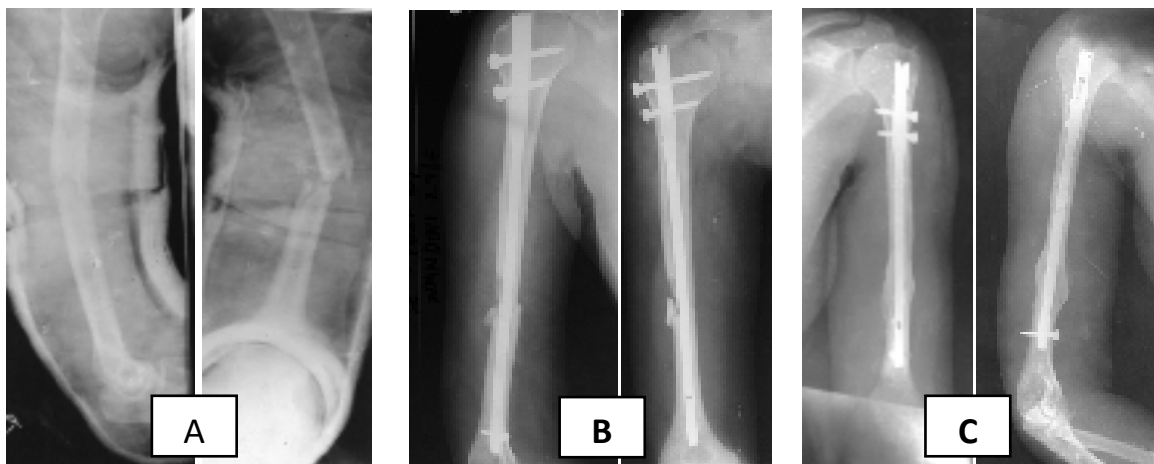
28 year old female fracture left humerus A-O type 12.B2 treated with Interlock nailing. (A) Pre-operative x-ray. (B) immediate post-operative x-ray. (C) 4 month post-operative x-ray.
